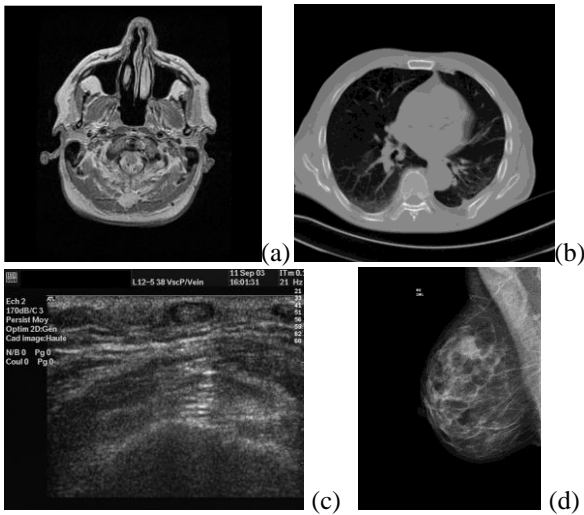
Samples of our experimental image data sets: (a) MRI (b) CT image; (c) X-Ray image; (d) Echography.
